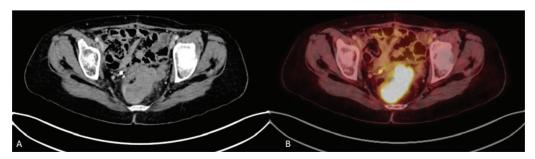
(A, B) CECT and FDG PET-CT showing recurrence along the wall of the rectum in a patient with carcinoma ovary post neoadjuvant chemotherapy, interval debulking followed by adjuvant chemotherapy with elevated CA-125 levels on follow up.
